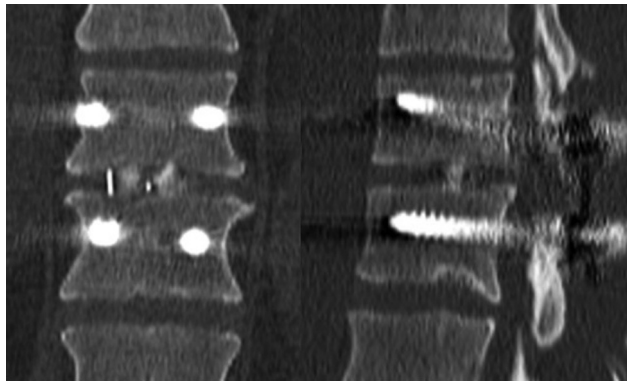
Sagittal and coronal reconstructions of spinal T12/L1 computed tomography (CT) scan depicting successful interbody fusion 18 months after surgery.
